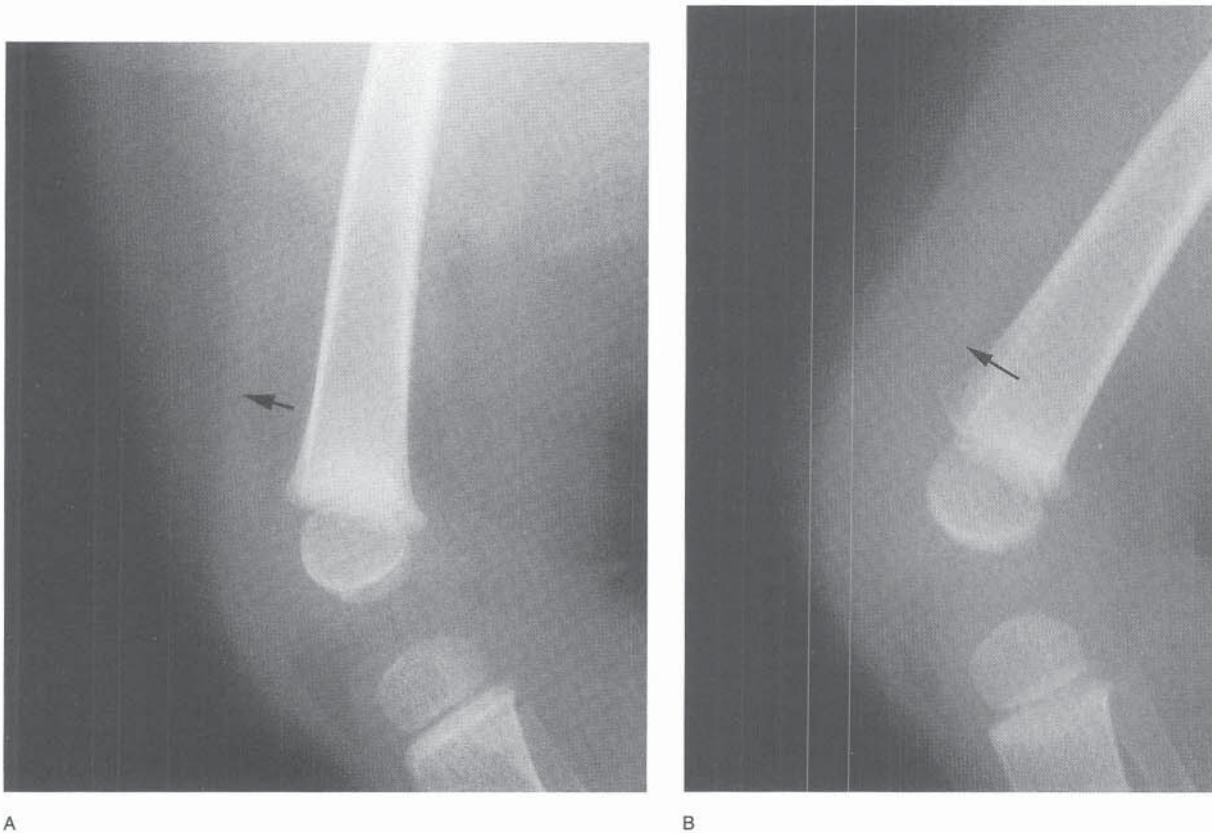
A, Lateral radiograph in normal 9-month-old child. Note the fat density along the anterior metaphysis of the distal femur. The soft tissue density between this fat pad and the subcutaneous fat represents the quadriceps tendon (*arrow*). B, Lateral radiograph in a 9-month-old child with a knee effusion. The increased soft tissue density between the suprapatellar fat pad and the subcutaneous fat represents an effusion (*arrow*).
